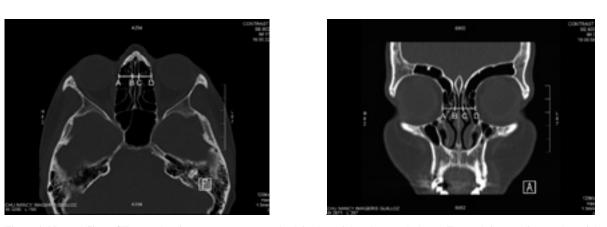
Normal Sinus CT-scan showing measurement method, in the axial and coronal planes. For each image slice on the axial and coronal planes containing the ocular globe (i.e. the anterior olfactory area) measurements were taken. BC distance corresponds to the maximum olfactory clefts width (MOC) in that image, within the plane of the ocular globe. AD distance corresponds to the total nasal width (TN). BC/AD is the proportion of the maximum olfactory cleft width to total nasal fossa width (MOC/TN).
